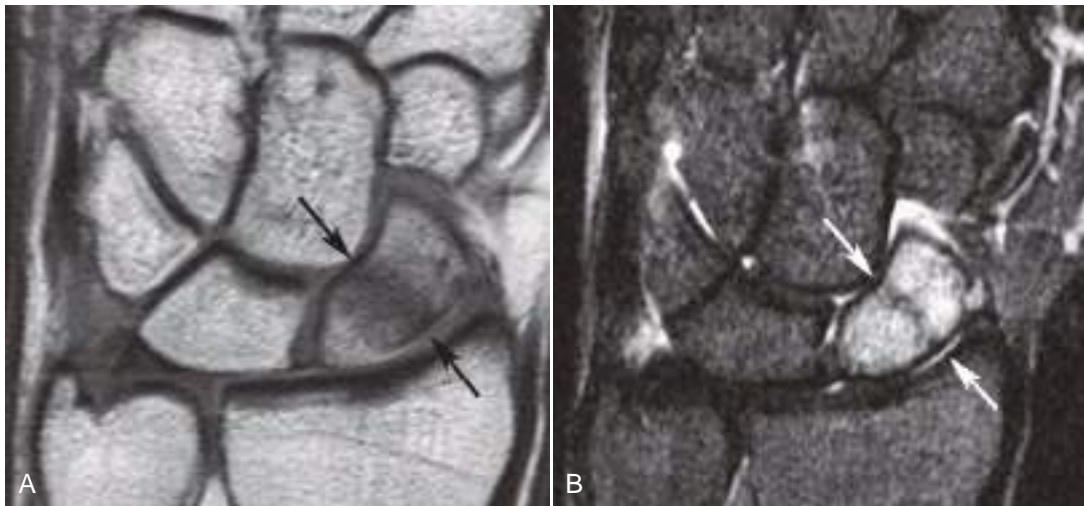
MR imaging of a radiographically occult fracture. Young adult with snuff box tenderness and normal radiographs. Coronal T1-weighted (A) and inversion recovery (B) images show a scaphoid waist fracture (arrows). Note the diffuse high-signal marrow edema in B.
